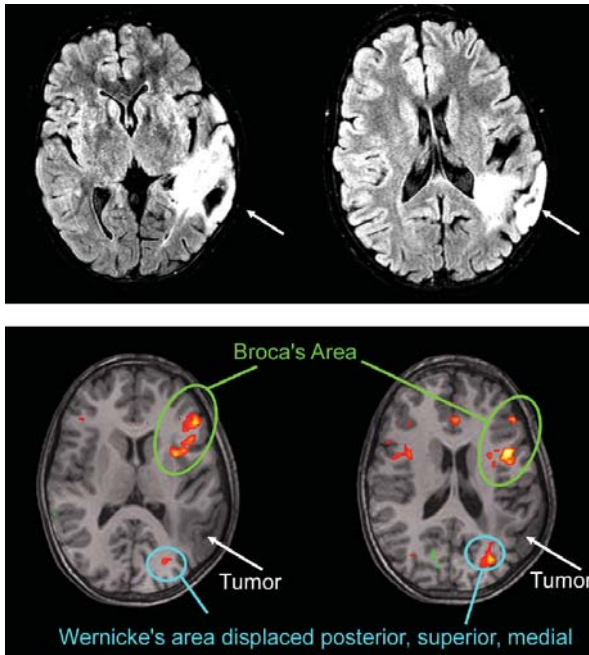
Presurgical planning requires knowledge of eloquent areas of cortex. This example presents a case where a left temporal lobe tumor, conspicuous on the FLAIR images, has displaced Wernicke's area (Images courtesy of Tim Roberts, PhD, Children's Hospital of Philadelphia).
